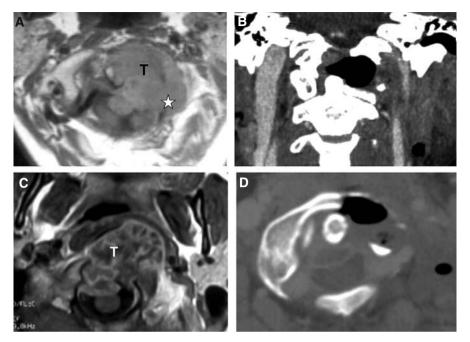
Chordomas. Pre-operative MRI axial view at the level of C1 (A) and of the occipital condyle (C). *T* tumor. *White star* Vertebral Artery. Post-operative coronal (B) and axial views (D) showing the tumoral resection through antero-lateral approach
